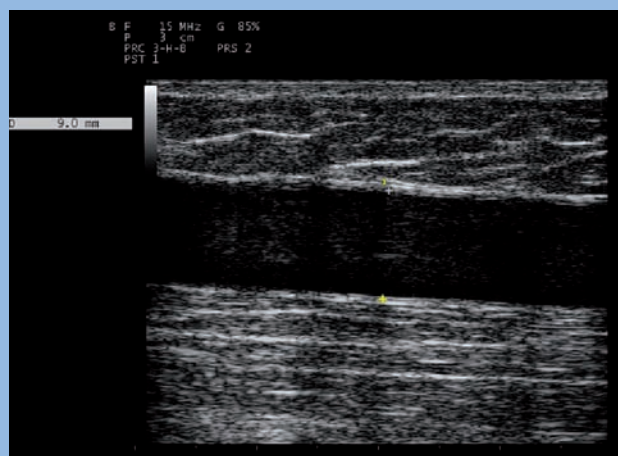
Ultrasound appearance of great saphenous vein (GSV), longitudinal scan.
